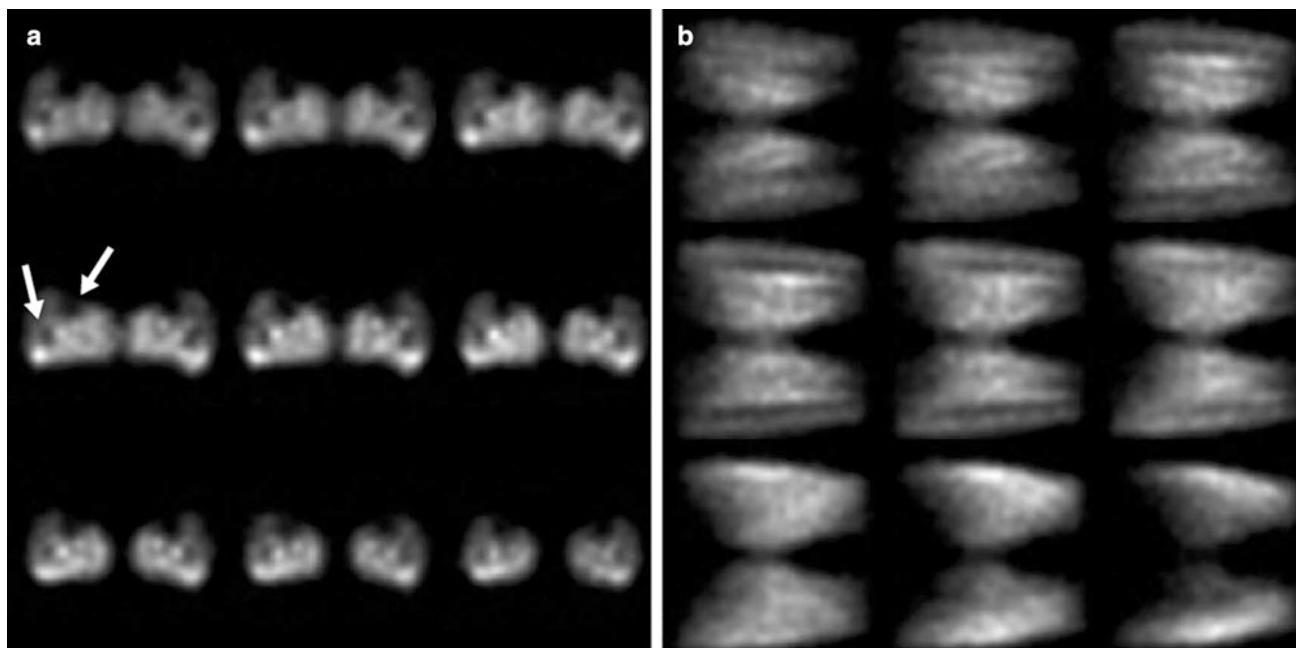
In vivo natural abundance ^{17}O MRI of a healthy subject. Transversal (a) and coronal (b) slices of both lower legs. In an acquisition time of 10 min a nominal spatial resolution of $(6.2 \text{ mm})^3$
